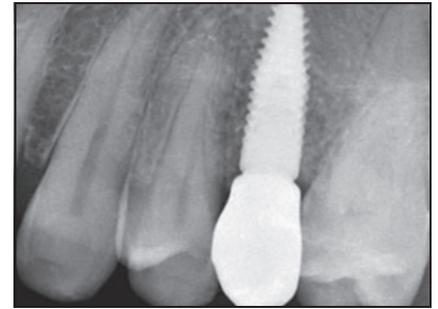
Intraoral radiograph 1 year after implant placement showing stability of marginal bone levels.
